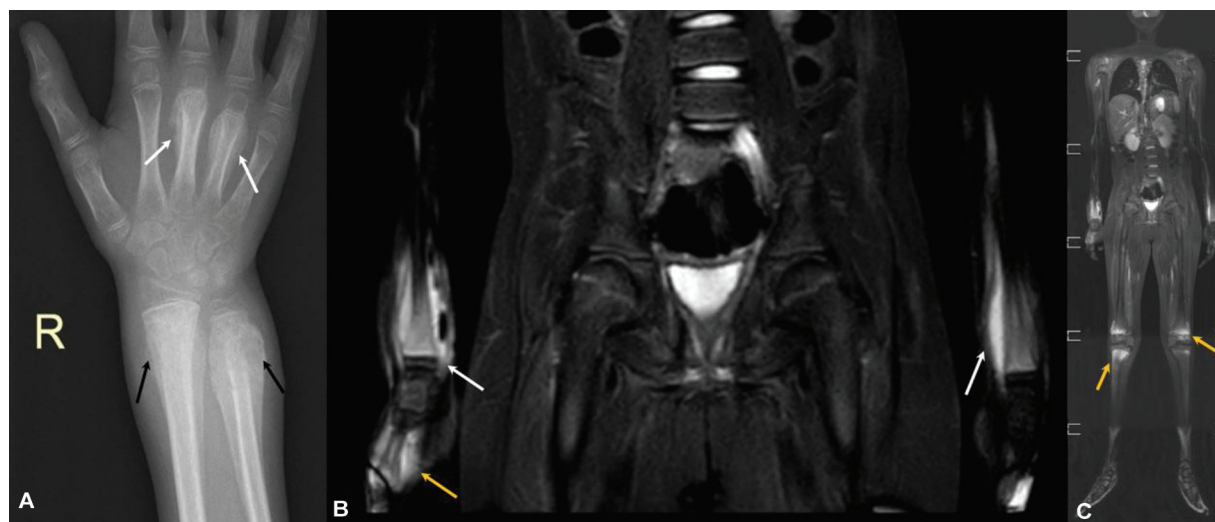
Chronic nonbacterial osteomyelitis (CNO) in a 9-year-old male who complained of recurrent pain and swelling in bilateral wrist and knee joints. (A) Posteroanterior (PA) view radiograph of the right wrist demonstrates exuberant hyperostosis and solid periosteal reaction centered at the distal ulnar and radial metaphyses (black arrows, A) with similar changes in shafts of 3rd and 4th metacarpals (white arrows). (B) Coronal short tau inversion recovery (STIR) whole body magnetic resonance imaging (WBMRI) at the level of forearm shows hyperintense marrow alteration within the distal metaphysis and adjacent diaphysis of bilateral radii (white arrows) and right metacarpal (yellow arrow) with hyperintense signal in the subperiosteal plane and adjacent soft tissues. (C) Stitched coronal STIR WBMRI image in the same patient provides a review of the entire body and additionally shows similar signal abnormality at bilateral distal femoral and proximal tibial metaphyses in periphyseal location (yellow arrows). The pattern of involvement is consistent with “multifocal tibio- appendicular pattern” of CNO.
